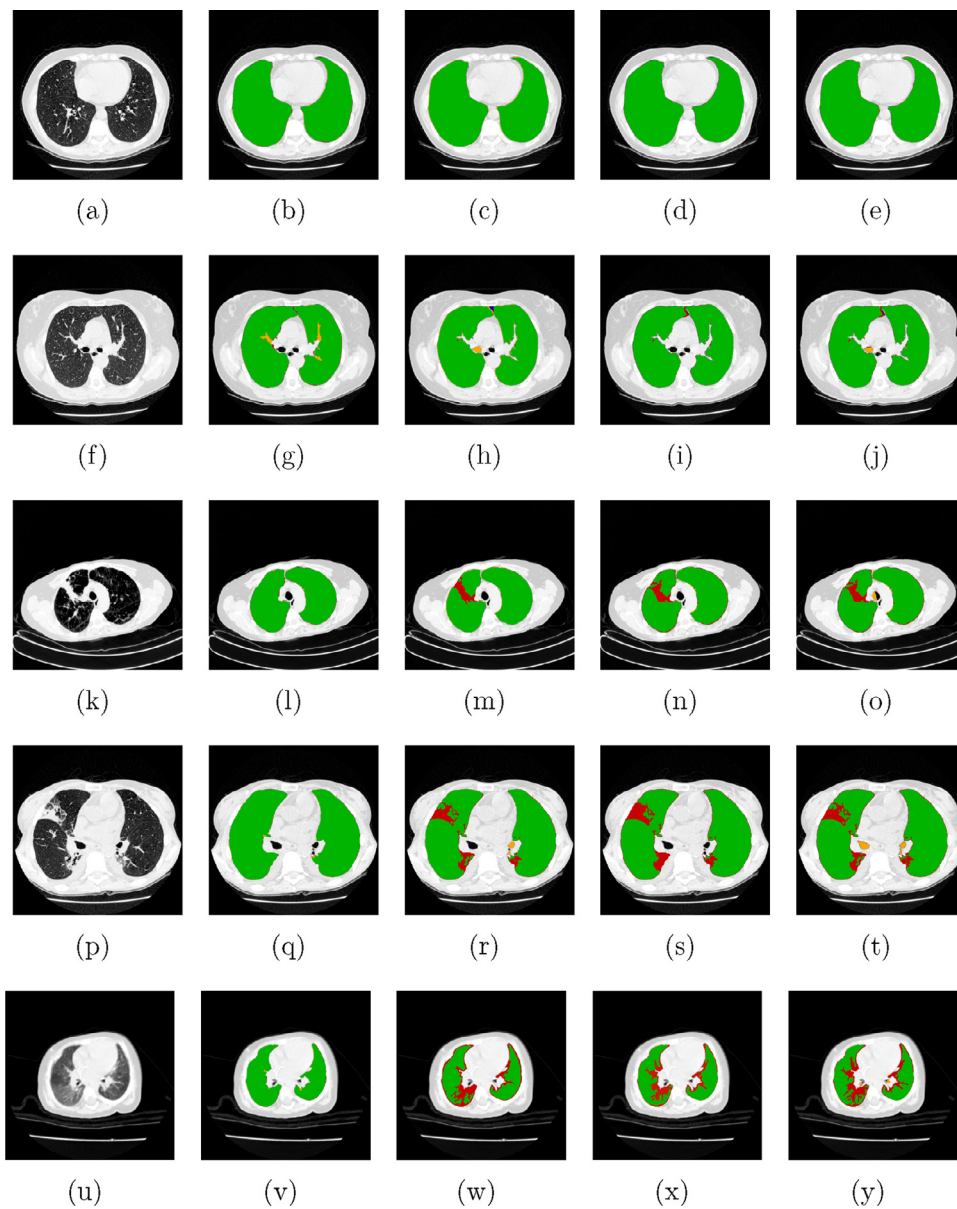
Examples of lung segmentations in CT scans obtained by the different methods under evaluation: a), f), k), p), u) original images; b), g), l), q) and v) 3D Adaptive Crisp ACM; c), h), m), r) and w) 3D Region Growing; d), i), n), s) and x) Level-set algorithm based on the coherent propagation method; and e), j), o), t) and y) semi-automatic segmentation by expert using the 3D OsiriX toolbox.
